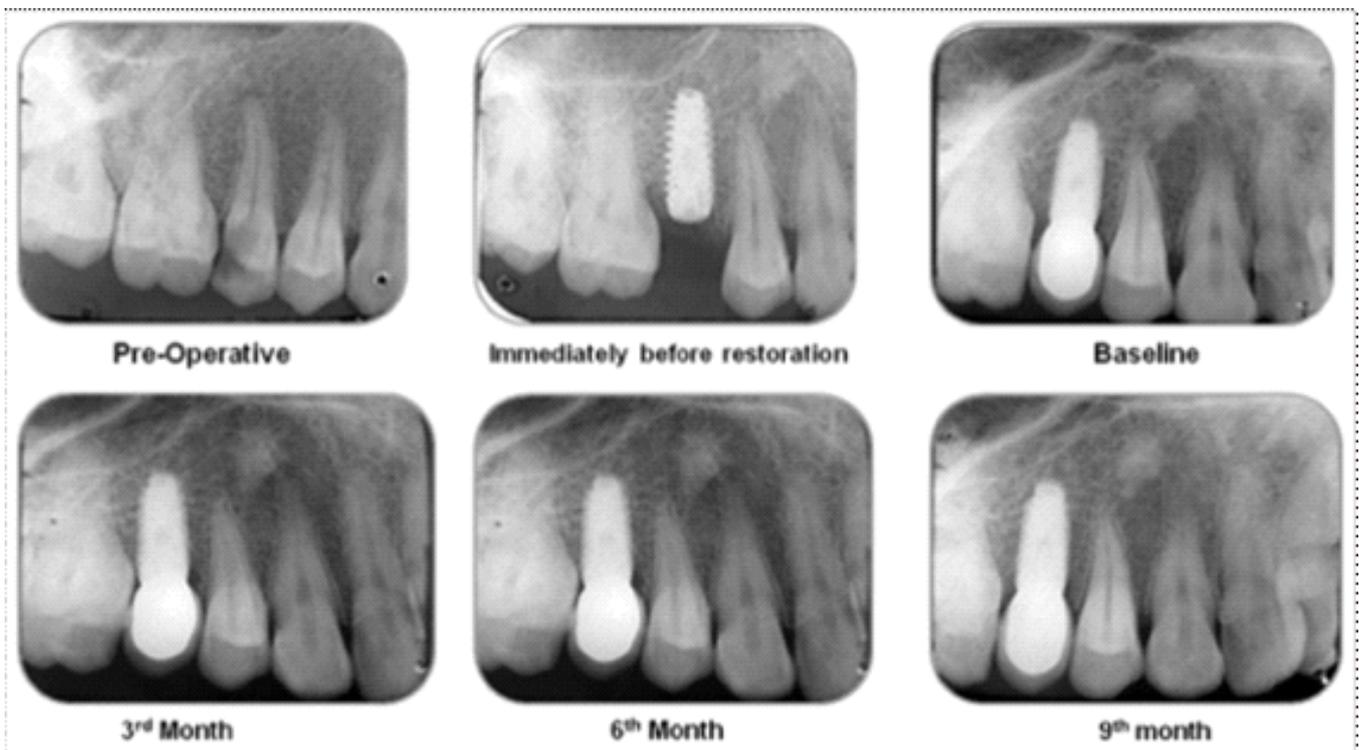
Radiographs at baseline, 3 months, 6 months and 9 months for implants placed in immediate extraction site.
